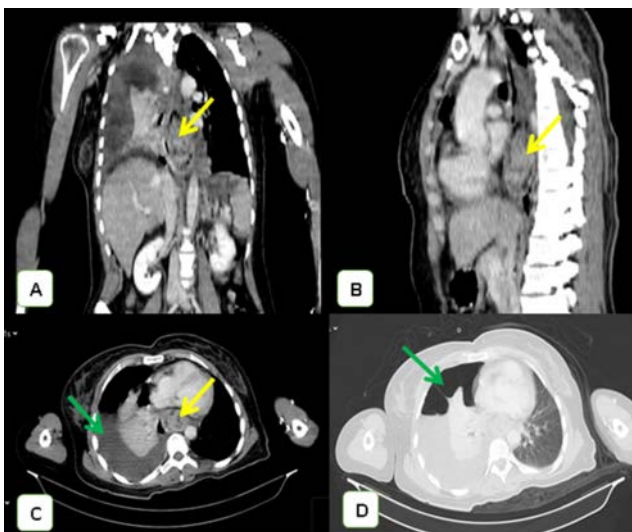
CT scan of the thorax and abdomen. Coronal (A), sagittal (B) and mediastinal window (C) view showing the trichobezoar (yellow arrow), the empyema (C) and the pneumothorax (D) (green arrow).
